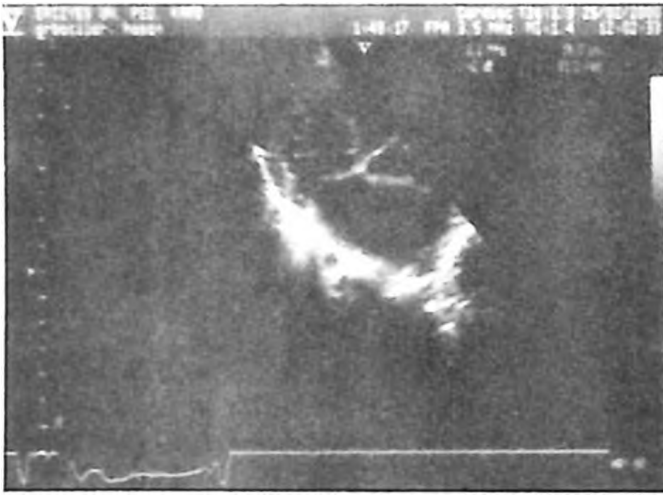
Apical long axis view of the left ventricle (transthoracic echocardiography). Spongy myocardial appearance resulting from abundant myocardial trabeculations and intertrabecular recesses.
